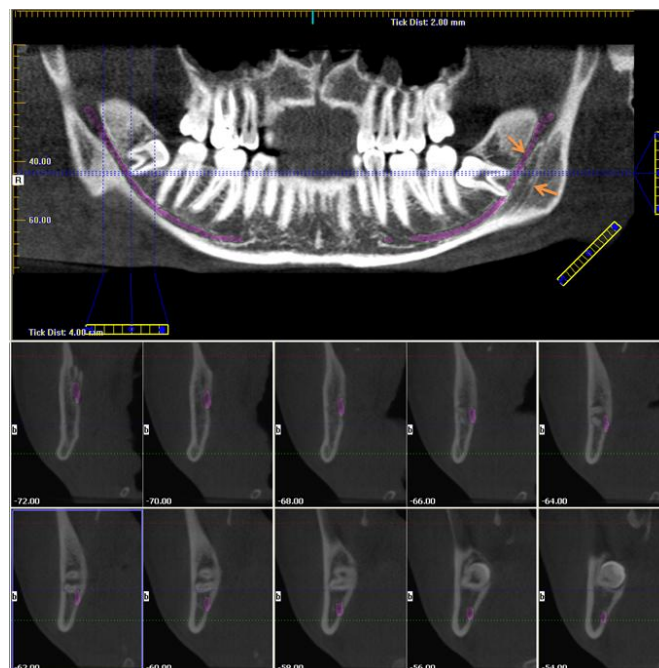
A CBCT panoramic reconstruction and cross sectional cuts showing the path of the MC; to note the left double MC (arrows)
